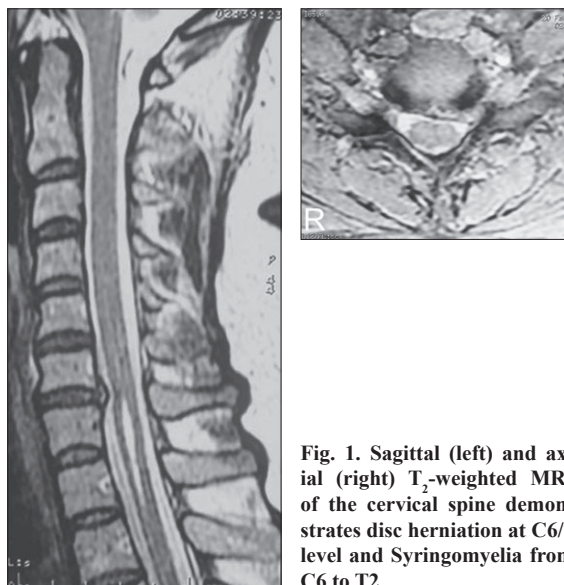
Sagittal (left) and axial (right) T₂-weighted MRI of the cervical spine demonstrates disc herniation at C6/7 level and Syringomyelia from C6 to T2.
